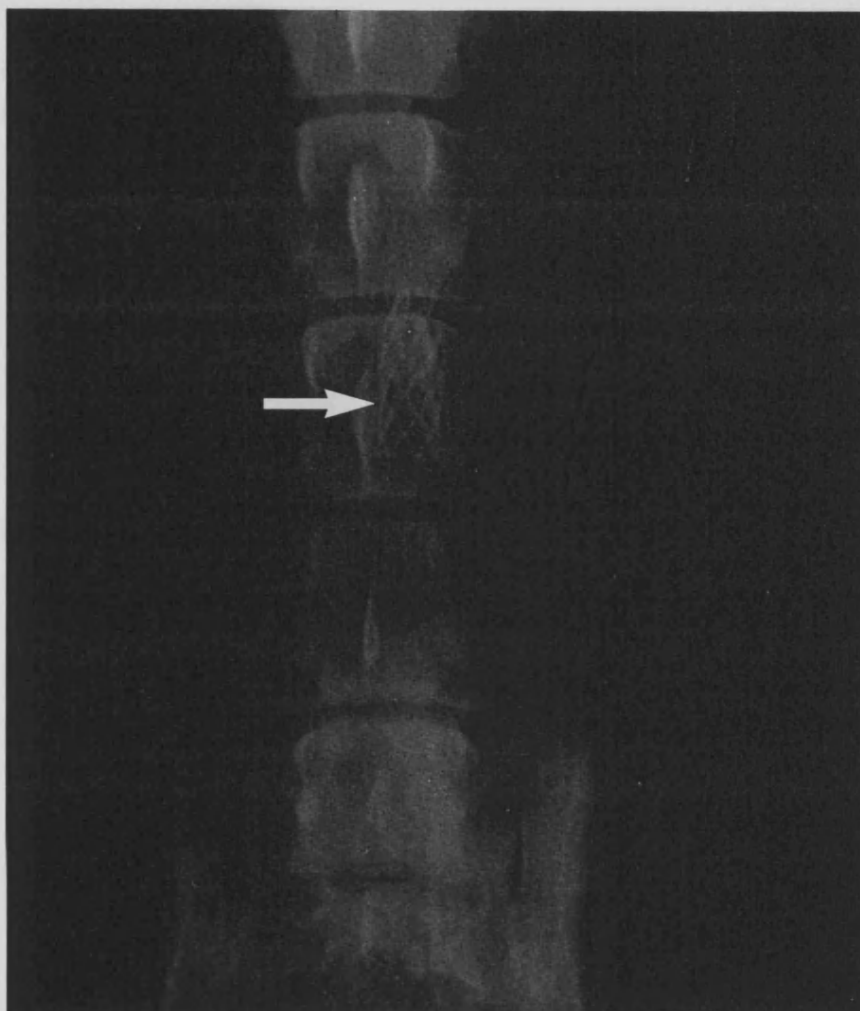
Plain radiograph showing satisfactory expansion of the proximal stent.
